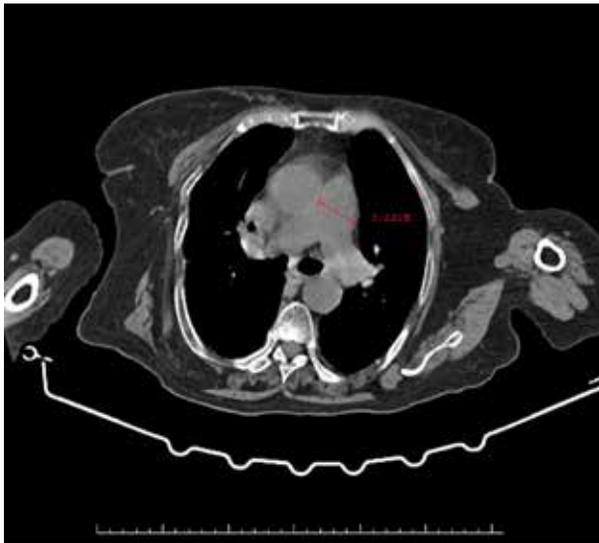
The main pulmonary artery diameter appears widened on the non-contrast chest CT result.
